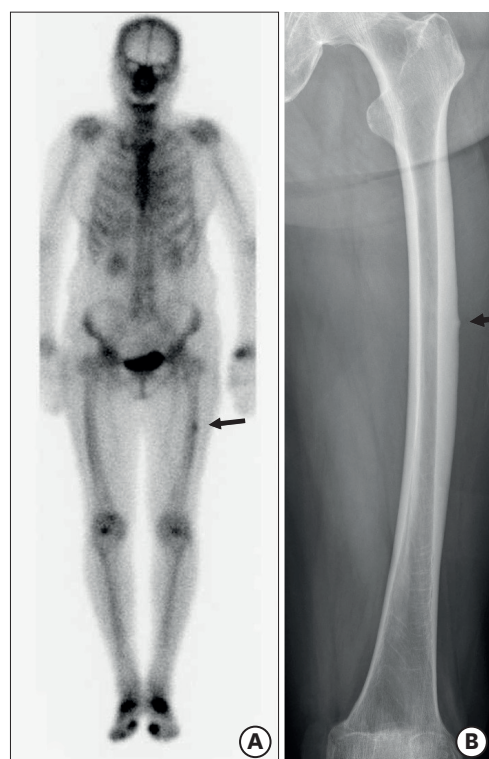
An 81-year-old woman had left thigh pain for 2 months. (A) Bone scan showed hot uptake (positive finding) at the middle of femoral shaft, and (B) anteroposterior radiograph of femur revealed atypical femoral incomplete fracture. She did not have any pain or complete fracture at 11 months later.
